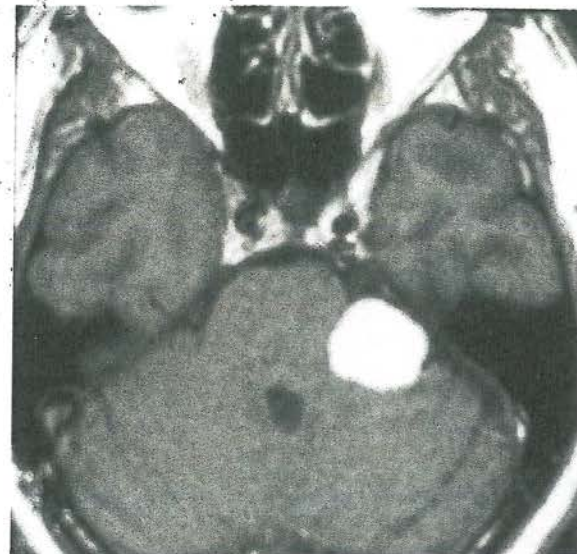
Axial T1-weighted MRI scan with enhancement showing an acoustic neuroma
